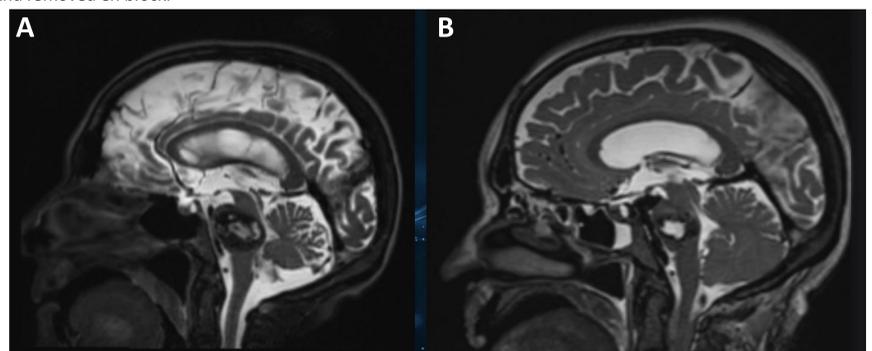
MRI Brain T2 weighted sagittal views comparing the preoperative (A) and postoperative (B) scans. This demonstrates a complete resection of the pontine cavernous malformation with expansion of previously effaced tracts.
